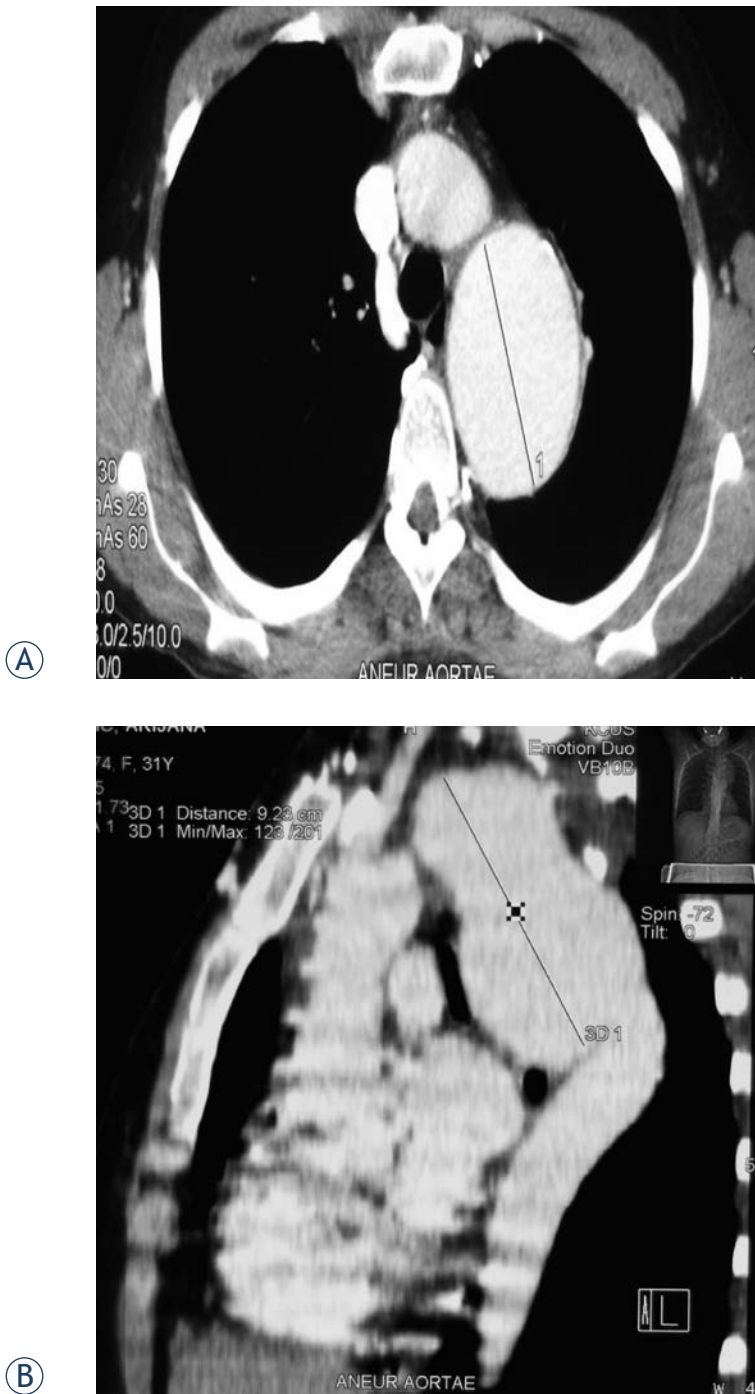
CT of posttraumatic pseudoaneurysm of the aortic isthmus.
